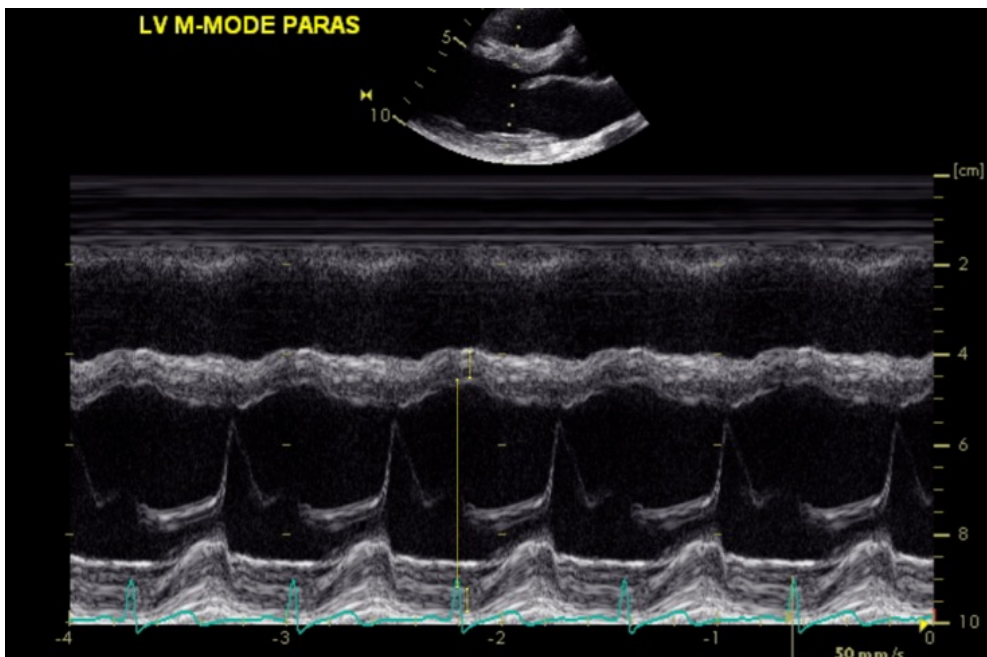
M-mode ultrasound image obtained during measurement of cardiac left ventricular mass. Reproduced with permission from the thesis by Mikola, (2018).
